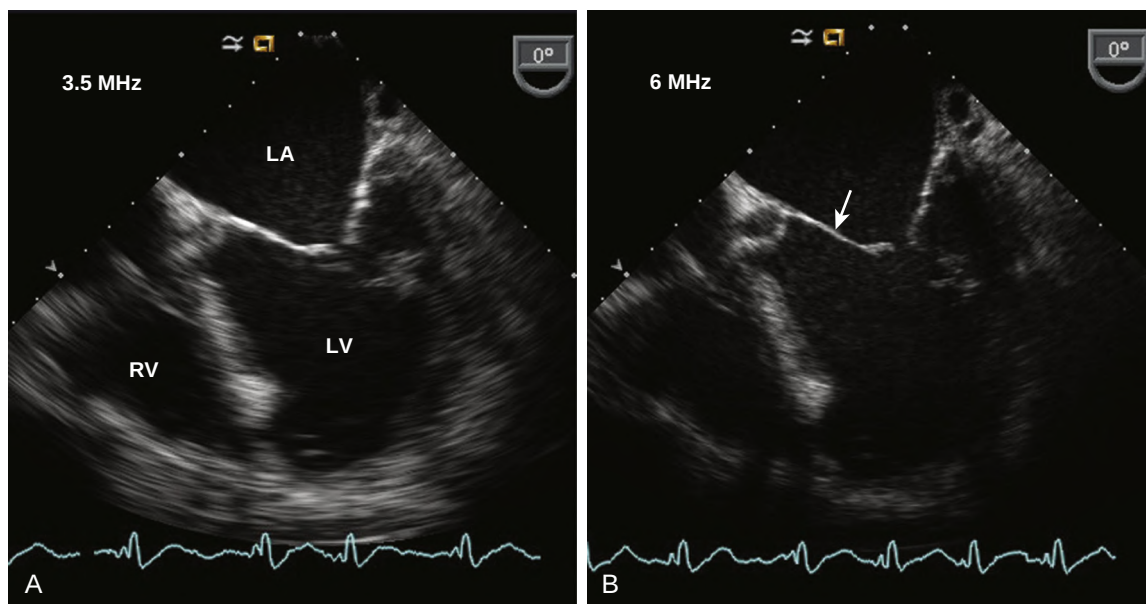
The effect of transducer frequency on penetration and resolution. In this transesophageal 4-chamber view recorded at a transmitted frequency of 3.5 MHz (A) and 6 MHz (B), the higher frequency transducer provides better resolution—for example, the mitral leaflets (*arrow*) look thin, but the depth of penetration of the signal is very poor, so the apical half of the LV is not seen. With the lower frequency transducer, improved tissue penetration provides a better image of the LV apex but image resolution is poorer, with the mitral leaflets looking thicker and less well defined.
